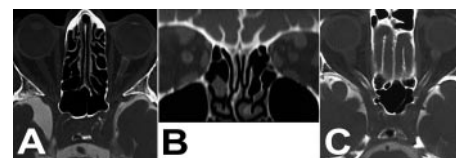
Two patients with ANTG. (A) Axial CT-cisternography demonstrating normal intracranial CLCSF signal. The right SAS of the optic nerve demonstrates a modest patchy filling signal of CLCSF while the left SAS is devoid of CLCSF. (B) CT-cisternography coronary view (same patient as A). Compared with the intracranial signal, the SAS of the right optic nerve shows only a modest signal of CLCSF while there is no CLCSF signal in the SAS of the left optic nerve. (C) Axial CT-cisternography. CLCSF reaches into the mid-orbital portion of both optic nerve.
